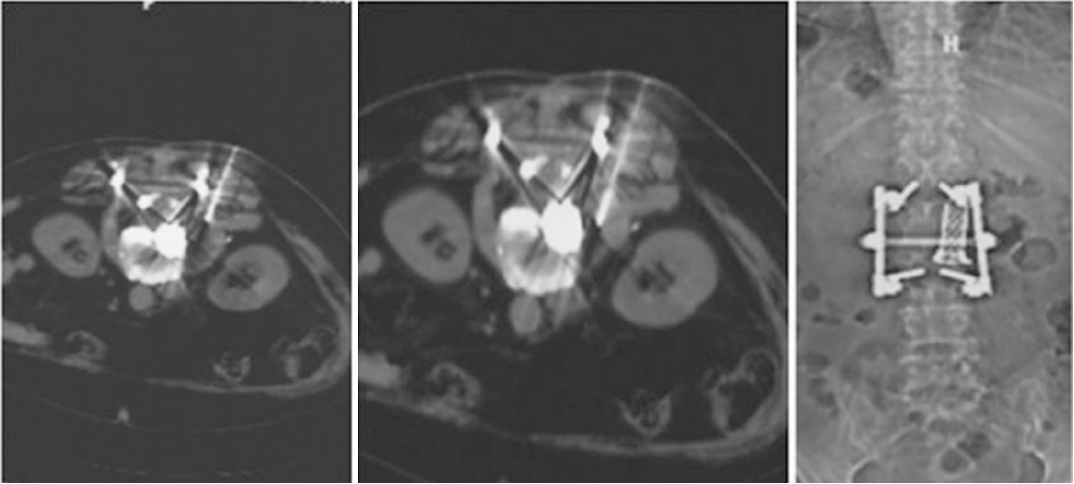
CT image showing correct positioning of the needle. Drainage of paravertebral liquid is feasible even in the presence of orthopedic devices
